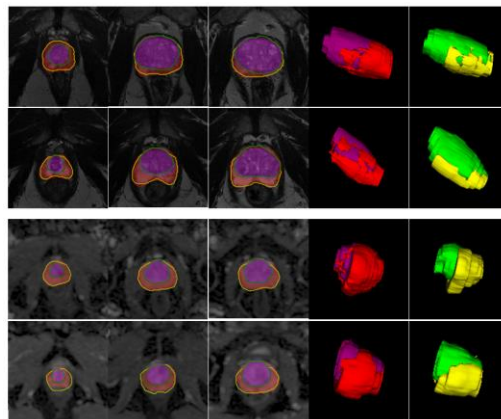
Example results from segmented prostate WG, CG, and PZ using T2W and ADC map MR images (two top and two bottom rows) in four patients. On the source 2D images, the U-net-based method segmentation of the prostate CG and PZ for three slices presented from apex to base (left to right) extracted from MRI are shown in purple and red respectively and the contours computed from the expert manual are displayed in green and yellow. The fourth and fifth picture elements depict a 3D surface rendering of algorithm-generated and expert manual segmentation of prostate zones respectively.
